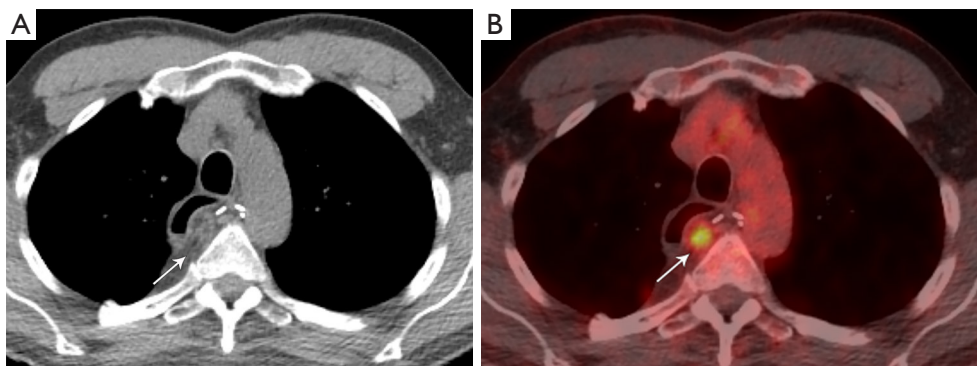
Fat necrosis. (A) CT shows oval lesion (arrow) posterior to the gastric pull-through in a patient treated for esophageal cancer. The lesion shows predominant fat attenuation demarcated by a soft tissue rim, typical of fat necrosis. (B) FDG PET/CT shows the fat necrosis (arrow) is FDG avid due to the inflammatory component and can be misinterpreted as tumor recurrence. CT, computed tomography; FDG, fluoro-2-deoxy-D-glucose; PET, positron emission tomography.
